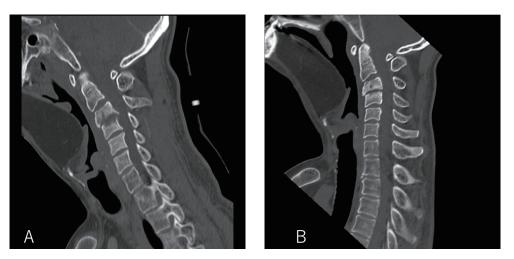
A Two months after the onset, CT showed pathological fractures in C3; however, the bone resorption of C3 and C4 vertebral bodies was reduced.B Six months after the onset, CT showed callus formation, and the line of cortical bone is visible.
